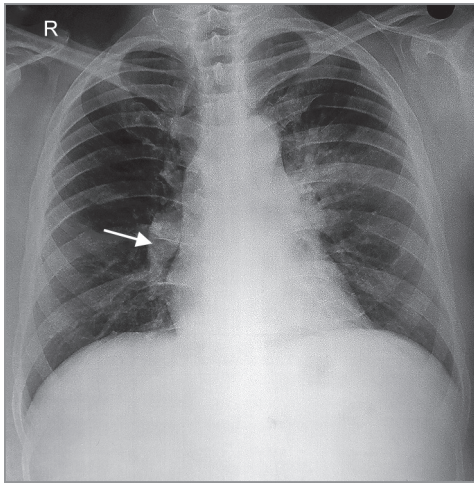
Chest X-ray PA view shows enlarged right pulmonary vasculature (arrow)
